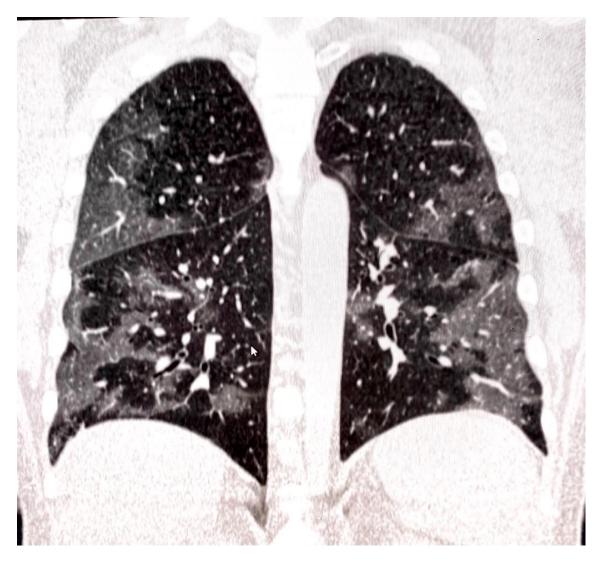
Chest Computed Tomography of the patient.
